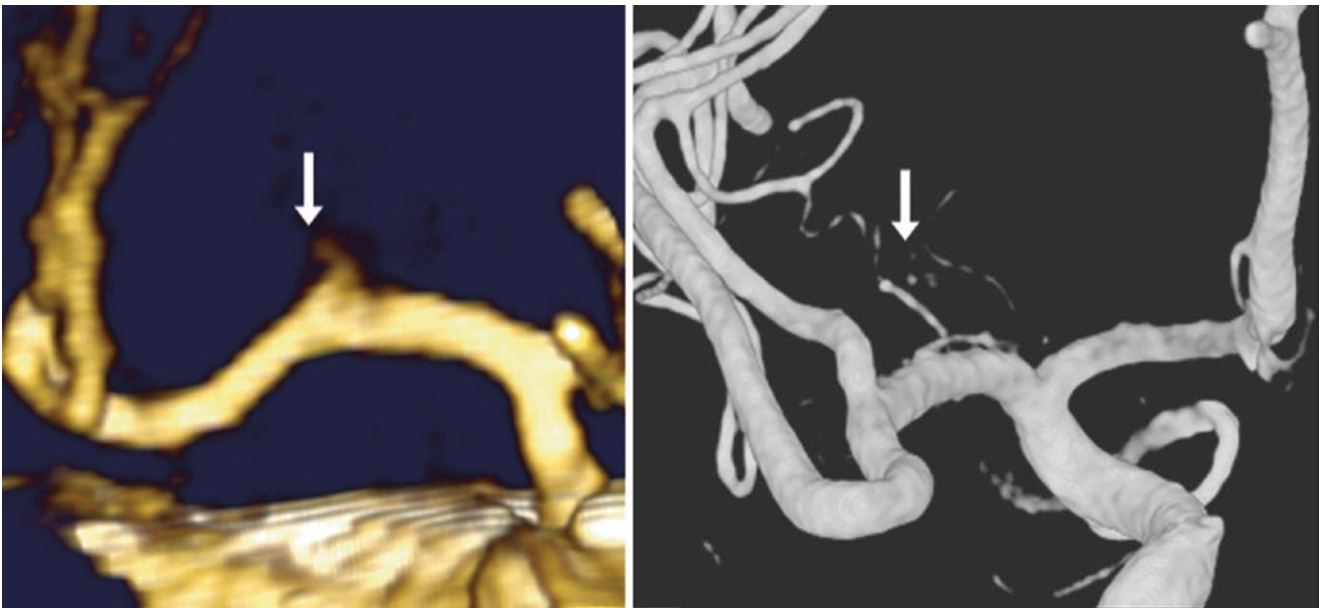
35-year-old with lenticulostriate branches (*arrows*) off the left MCA on AP views from a 3D VR CTA (*left*) and a 3D DSA (*right*)
